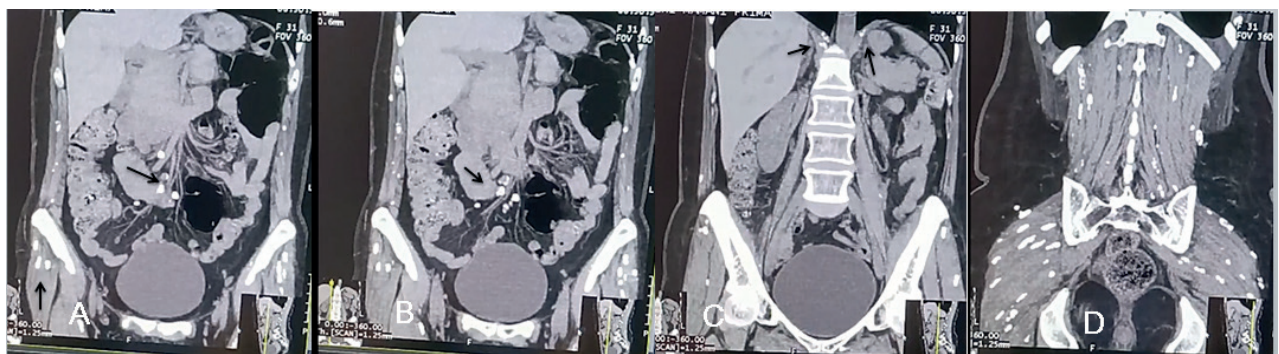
Plain CT of the abdomen, coronal reconstructions. Small hyperdense images, calcific density associated with calcifications (arrows). A and B: pelvic muscles and mesenteric lymph nodes. C: both hemidiaphragms. D: dorsal and gluteal muscles
